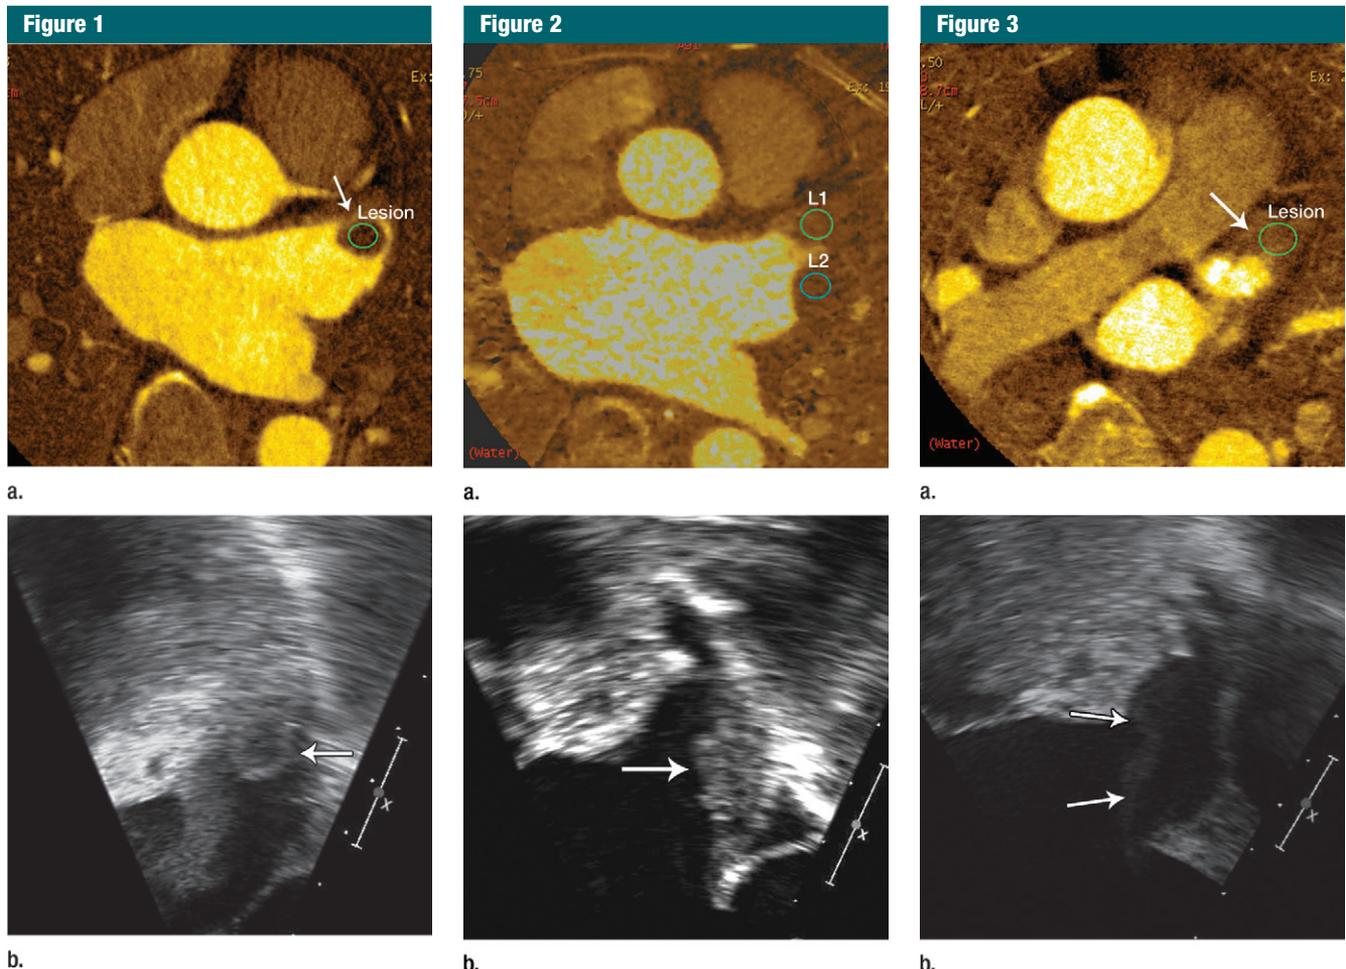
Dual-energy cardiac CT and TEE images in 79-year-old man with stroke and an LAA thrombus. (a) Axial CT iodine map shows filling defect in LAA; the mean iodine concentration within the ROI was 1.34 mg/mL. (b) TEE image shows thrombus (arrow) in the LAA.
